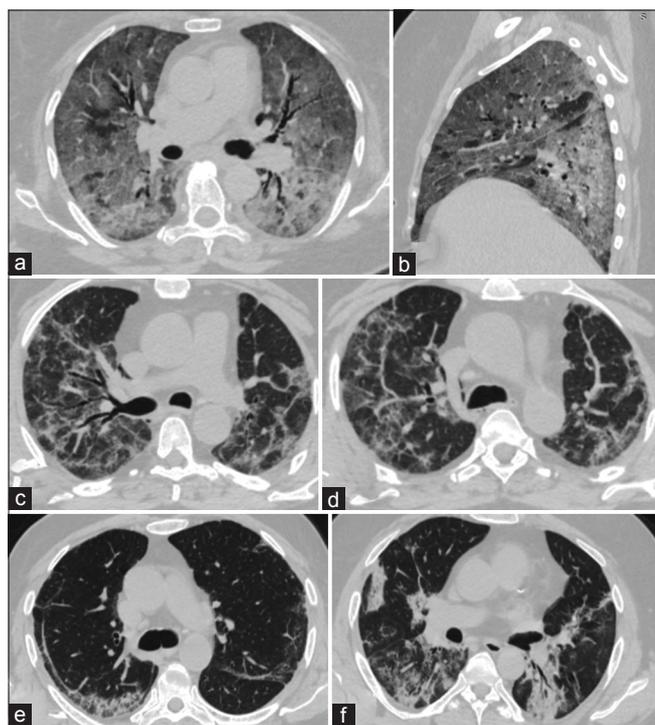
Axial and sagittal computed tomography (CT) images showing ground glass opacities (GGOs) with ILST giving a Crazy paving pattern (a and b). CT images of a patient showing bronchial distortion, vascular dilatation, linear opacities, fibrous stripes, and spontaneous pneumomediastinum (c and d). Axial chest CT image (e) showing subpleural curvilinear lines and linear opacities. Image (f) shows GGOs with patchy consolidation with air bronchogram in the left lower lobe
